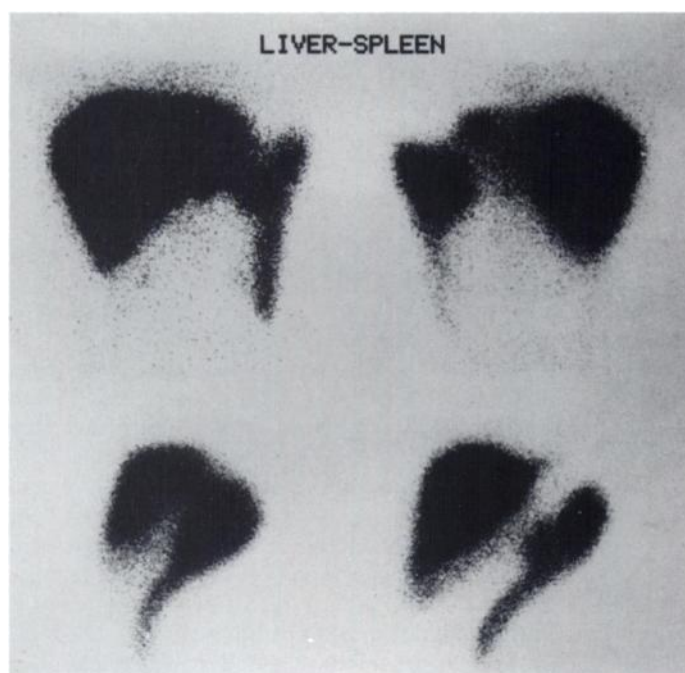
Planar radiocolloid scintigram of the liver and spleen. Note the tail-like extension of splenic tissue to the lower abdomen. The film is slightly overexposed to show better the thin cord of splenic tissue.
